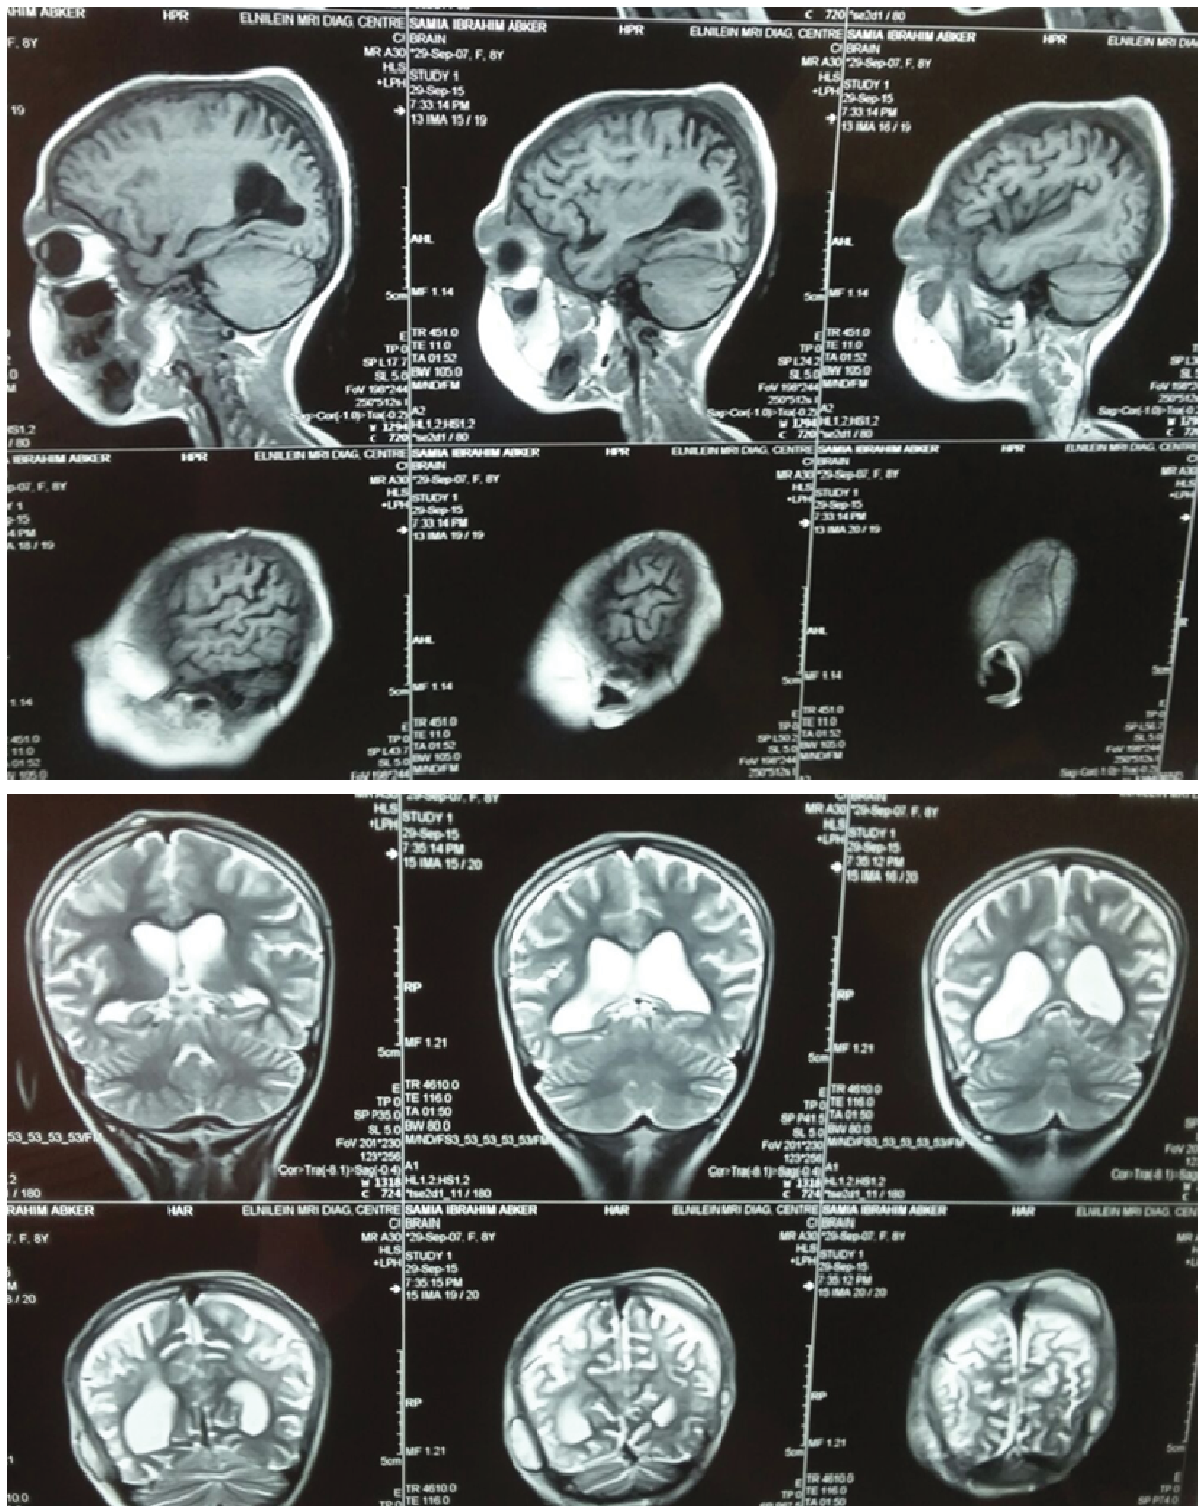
Brain MRI displayed: Multiple small pocket collection noted in different sites in the scalp prominent in the temporal and parietal areas.
